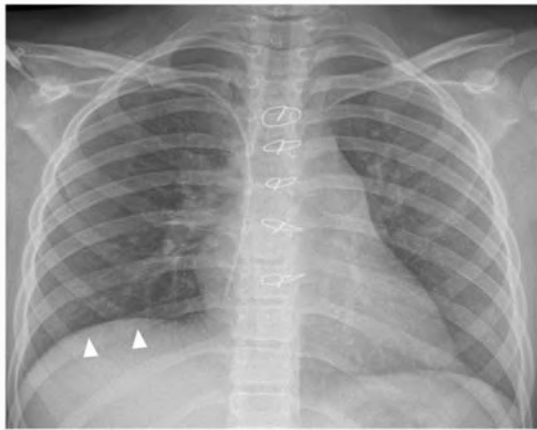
A chest X-ray obtained in the early postoperative period. The previously seen mediastinal mass (pointed by arrows in Figure 1) is no longer visualized. Elevation of right hemidiaphragm (arrowheads) is likely related to partial resection of the right phrenic nerve, which was encased by the mediastinal mass. Sternal wires after median sternotomy are also noted.
